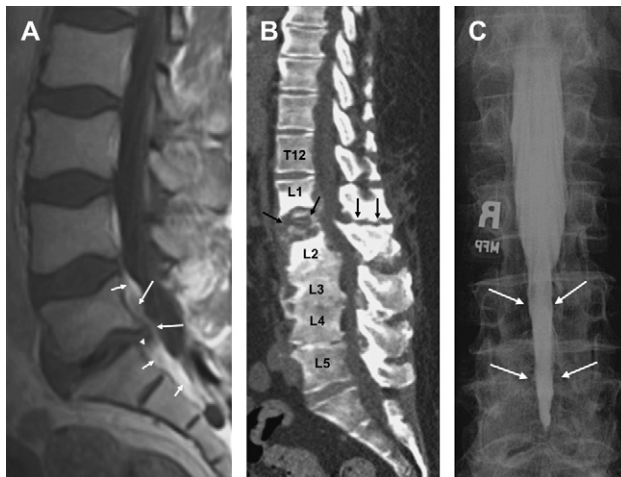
Postoperative spine. (A) Epidural scar. Sagittal T1 post contrast—same patient as in Fig. 9C. Residual or recurrent small disk protrusion (*arrowhead*) surrounded by mildly enhancing epidural scarring (*long arrows*). Note more prominent surrounding hyperintensity resulting from epidural fat and enhancing epidural venous plexus (*small arrows*). (B) Pseudoarthrosis. Sagittal CT—L1-2 anterior and posterior column aligned lucency (*arrows*) resulting from abnormal motion. Note L2-3 and L3-4 anterior fusion. (C) Arachnoiditis. Conventional postero-anterior myelogram—tapered lumbar myelographic block (*arrows*).
